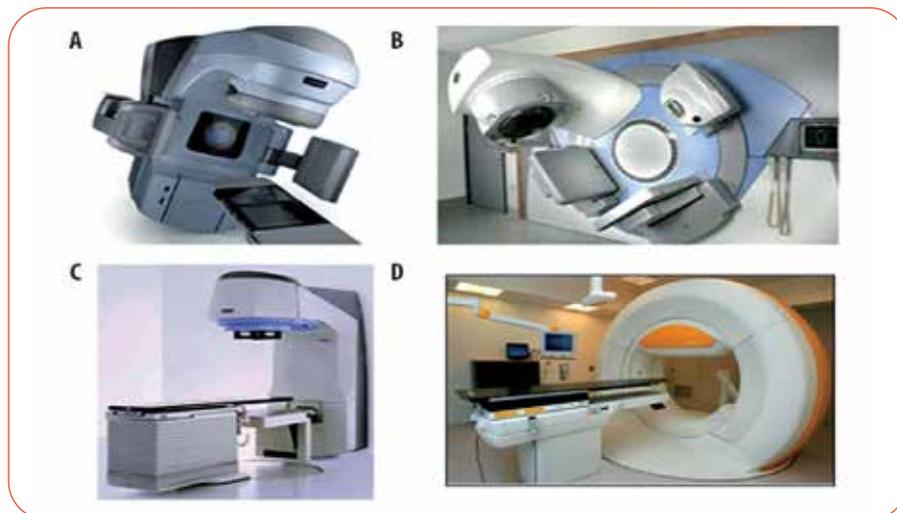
Cone beam systems mounted on medical linacs.
